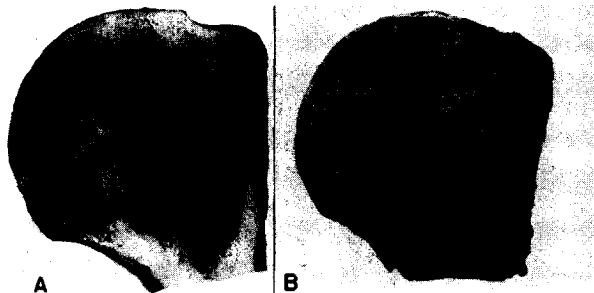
A, Slab radiograph of the humeral head in a compressed air worker known to have osteonecrosis. Serpiginous zone of increased density involves the large part of the femoral head (see B).
